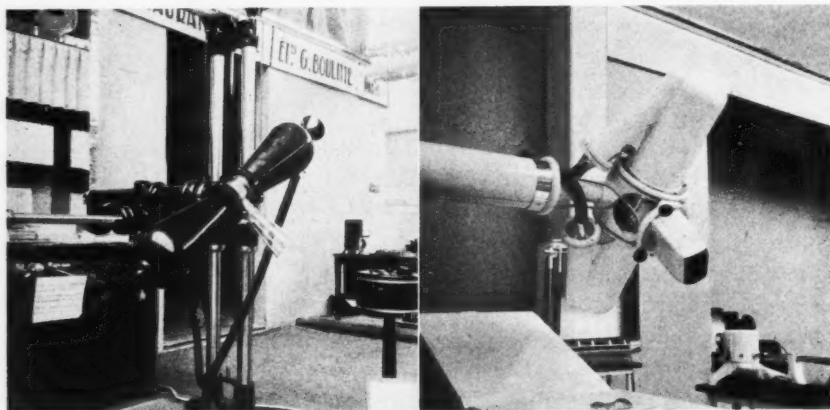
(left). A Metalix "autoprotective" tube is made shock-proof by enclosure in this metal shield. Air, bakelite, and rubber enter into this design. Anode cooling is by means of water, pumped through the anode (insulated) cable. This design may be had in various sizes, according to voltage requirements (cf. Fig. 4). All sizes are perfectly flexible and very compact, and, owing to the fact that the built-in X-ray shielding of the Metalix tube is ample, and is obtained with a minimum mass of lead, close to the X-ray source, the total weight of this shock-proof assembly is remarkably low. Originally designed for therapy, this design is now being manufactured for diagnostic work.
